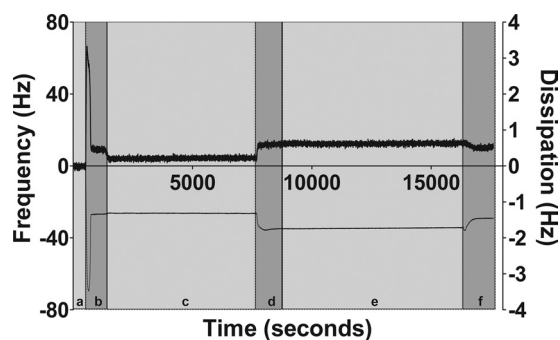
Typical QCM-D sensorgram. The lower line represents changes to the vibrational frequency of the QCM chip (Δf , left-hand axis), and the upper line is the dissipation of energy through the adsorbed lipid (ΔD , right-hand axis). Progress of the experiment is delineated by alternating light and dark gray shading corresponding with the symbols *a–f*. *a*, base-line condition under acetate buffer 50 mM, pH 5, with NaCl, 100 mM; this is the condition to which changes to Δf or ΔD are referenced. *b*, addition of lipid in the form of SUV (lipid in this example is POPC/POPS (2:1), pH 5), leading to the coating of the chip with the SUV (rapid decrease in Δf to around -60 Hz) and their breaking open to form a bilayer in contact with the QCM chip (rapid increase in Δf to a value around -30 Hz). *c*, wash with acetate buffer to remove extraneous SUV (slight increase in Δf and decrease in ΔD). *d*, injection of moPrP(23–89)-peptide leading to the adsorption of the peptide to the bilayer (rapid decrease in Δf to c , -40 Hz). *e*, incubation of peptide with bilayer with no resulting change to Δf or dissipation over time, indicating that the bilayer is not disrupted by the peptide. *f*, wash with acetate buffer causing dissociation of the peptide from the lipid rapid increase in Δf .
